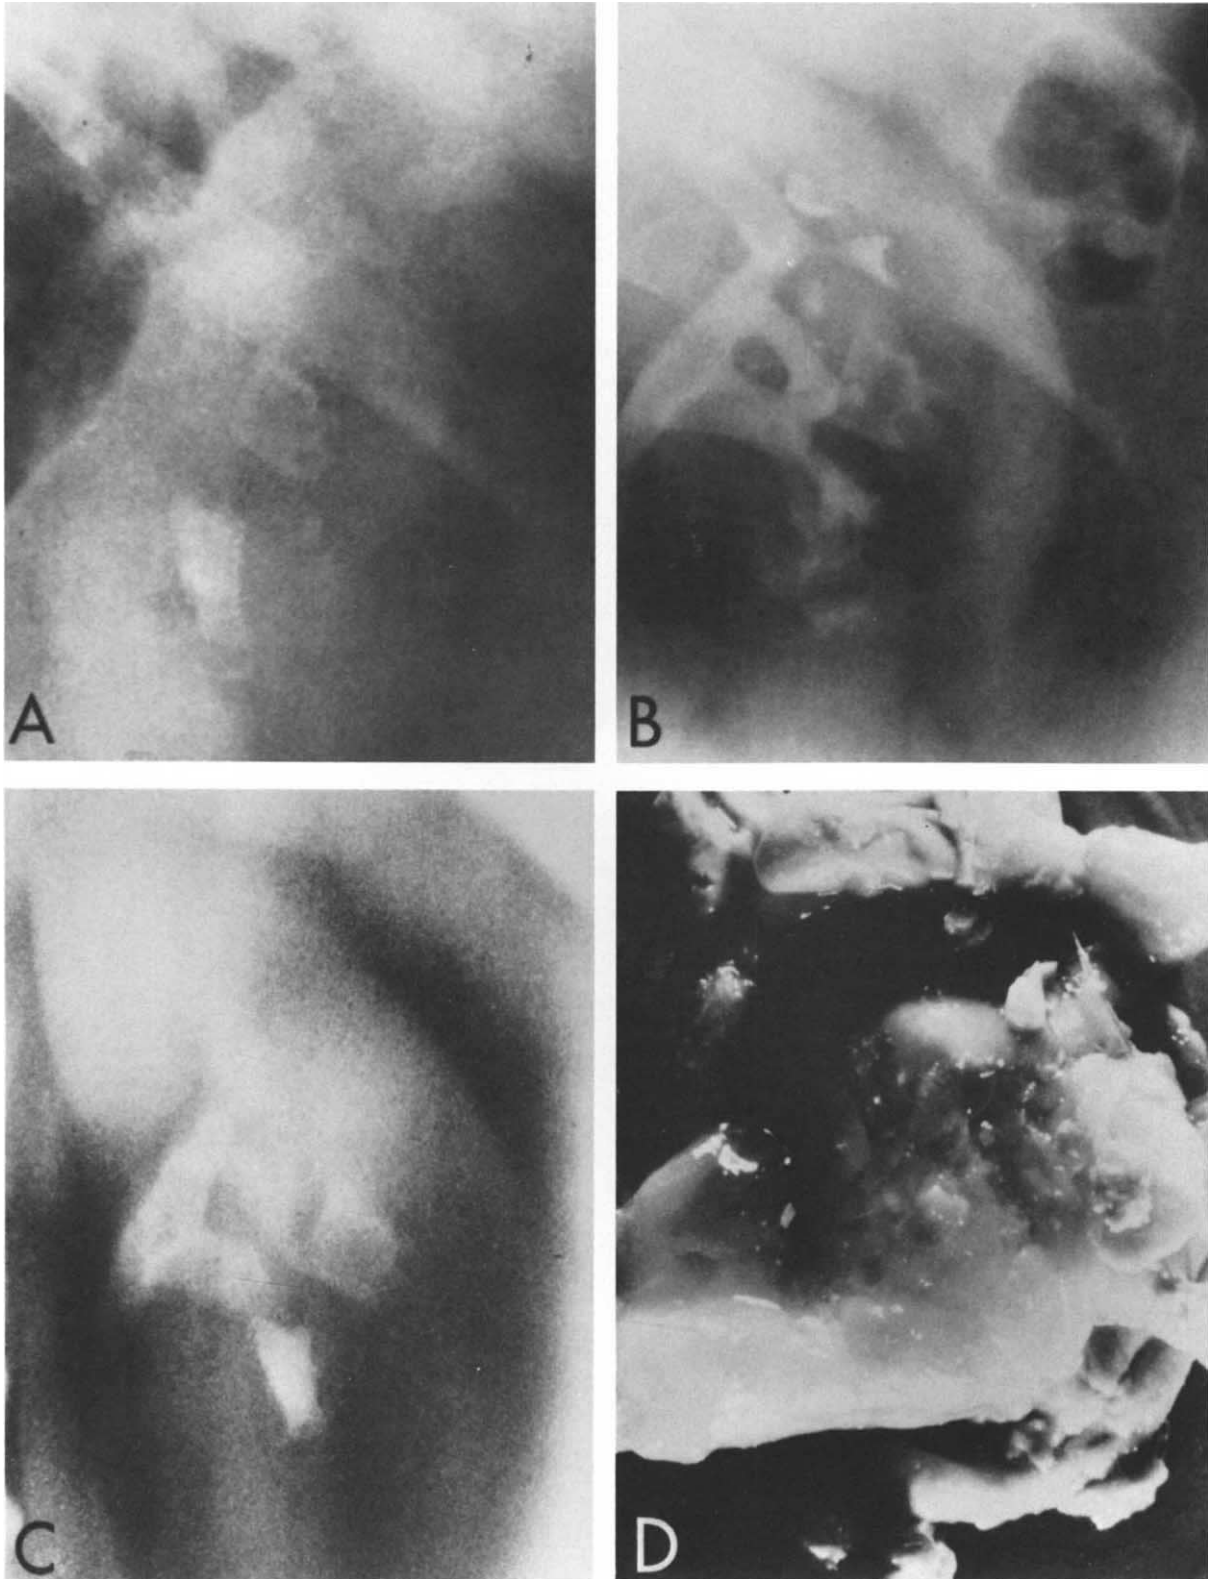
A calyceal stone is present on plain film. B. A radiolucent cast of the pyelocaliceal system is apparent on the urogram. (Reproduced from *Nephrolithiasis, Contemporary Issues in Nephrology*, vol. 5, edited by Fredric L. Coe, M.D., Barry M. Brenner, M.D., and Jay H. Stein, M.D. Copyright © 1980 by Churchill Livingstone. Reprinted with permission of Churchill Livingstone, New York.) C. A staghorn stone is apparent on plain film 6 weeks after original plain film (A). D. A portion of the matrix concretion was subsequently recovered. (Reproduced from *Nephrolithiasis, Contemporary Issues in Nephrology*, vol. 5, edited by Fredric L. Coe, M.D., Barry M. Brenner, M.D., and Jay H. Stein, M.D. Copyright © by Churchill Livingstone. Reprinted with permission of Churchill Livingstone, New York.)
